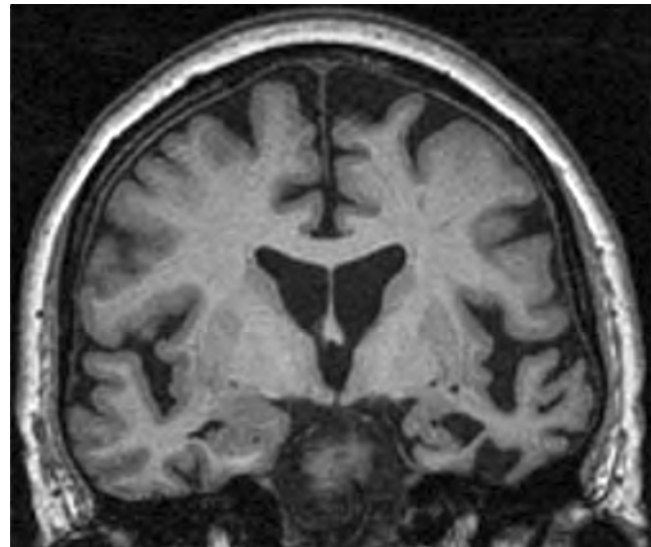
Coronal section of T1-weighted brain MRI showing focal atrophy predominantly involving the antero-inferior left temporal lobe, a pattern typical of semantic dementia.
